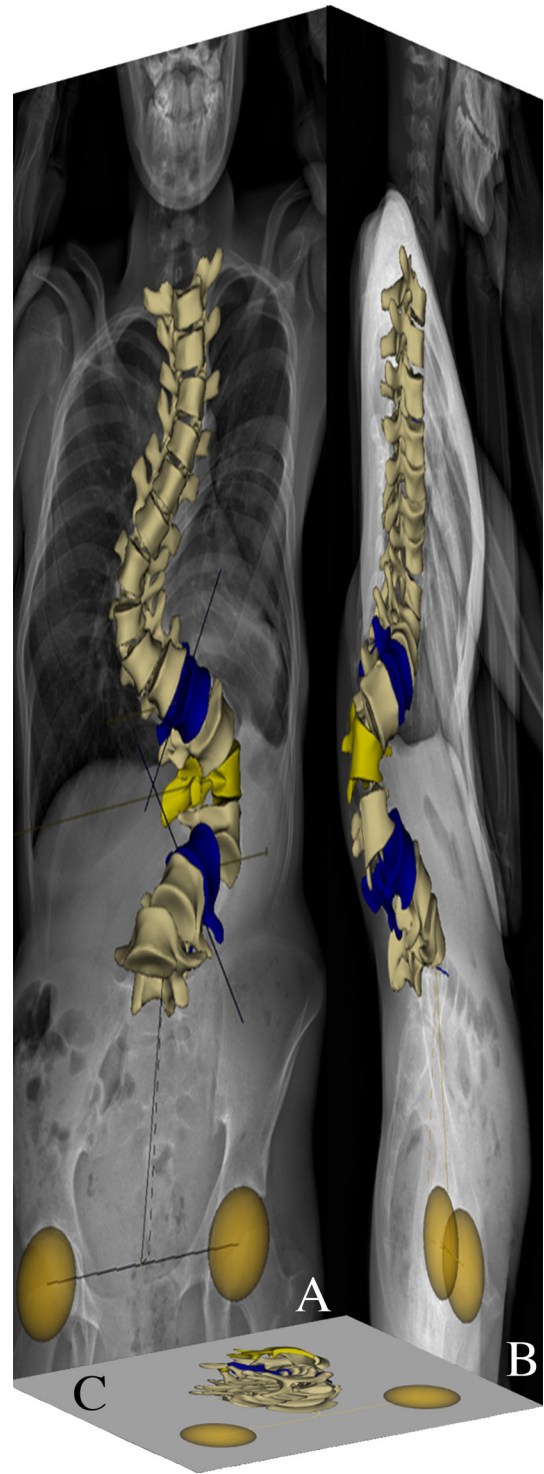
2D/3D EOS images in a patient with severe scoliosis. 3D reconstruction on the postero-anterior (A) and lateral (B) radiograph. 3D top view (C).
